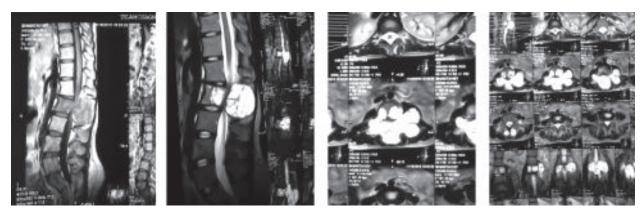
MRI of the dorsolumber spine showing Aneurysmal Bone Cyst of the L-2 vertebrae.
